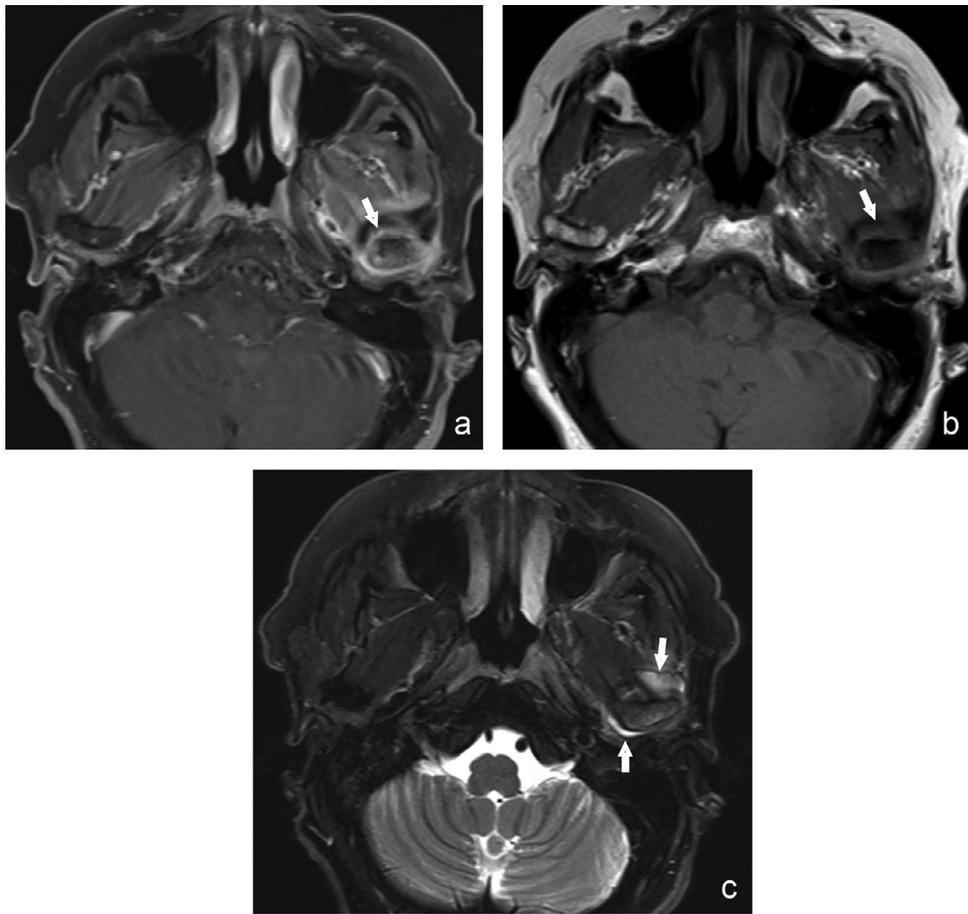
The appearance of rheumatoid arthritis on MR imaging: (a) T1 C+ FS shows enhancement of the vessel-rich inflamed synovial lining, (b) T1 shows no enhancement of the lining and, (c) T2 shows enhancement of the fluid within in the joint spaces. (Courtesy, R. Wiggins, MD).
